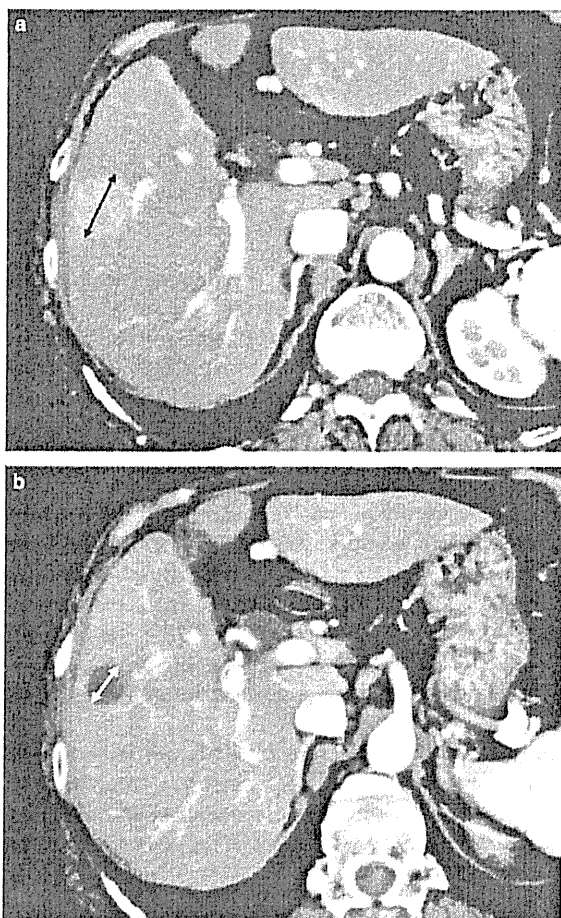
A: CT before TACE: Both criteria (RECIST version 1.1 and mRECIST) measured the longest diameter of the tumor. B: CT after TACE: The tumor had become entirely necrotic. The tumor response was evaluated as CR using mRECIST criteria (i.e. no measurement) and as non-CR using RECIST version 1.1 criteria (i.e. the measurement of the longest diameter of the entire tumor).
